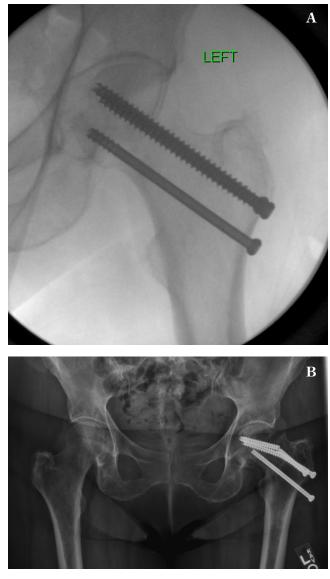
Initial radiograph of a nondisplaced femoral neck fracture treated with length stable fixation. 4b. Follow up radiograph at 8 weeks, demonstrating failure of fixation.
